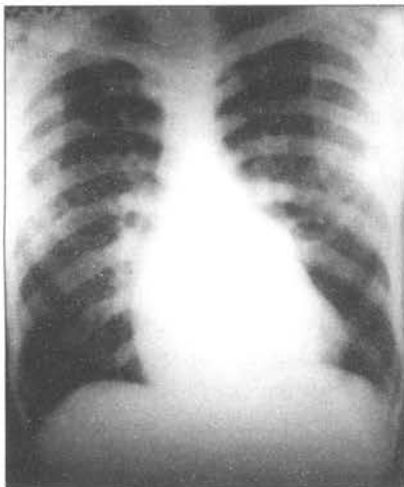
X-ray heart (PA view). Mitralised heart
